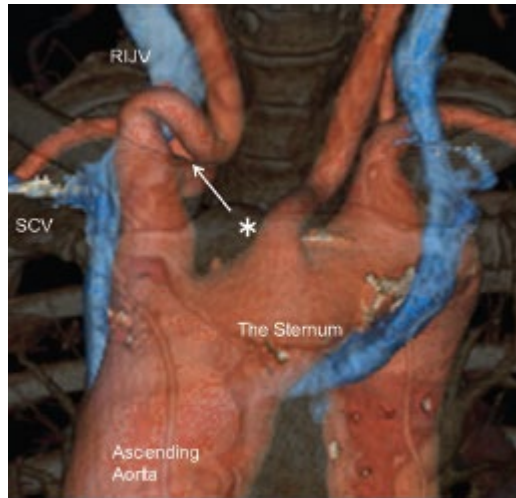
Computed tomographic angiography (front view) showing the tortuous right common carotid artery. *Tortuous common carotid artery. RIJV indicates right internal jugular vein; SCV, subclavian vein.
